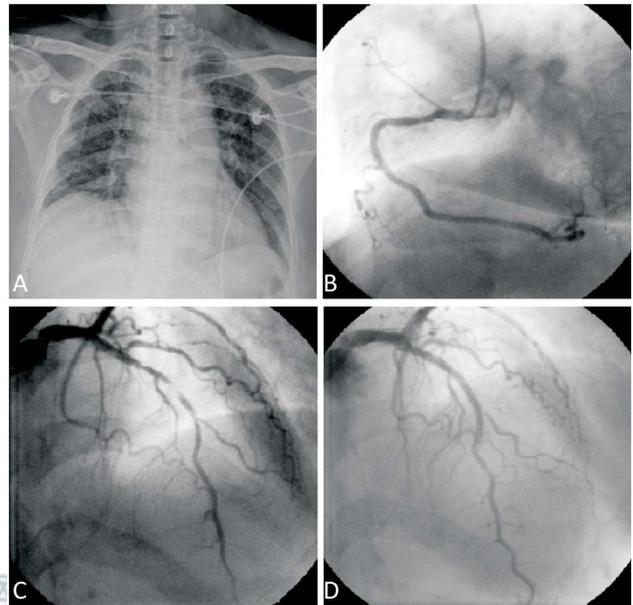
(A) Chest X-ray at emergency department showed mild lung congestion, suggesting reduced cardiac contractility. CAG in the next day revealed (B) RCA atherosclerosis and (C) proximal-to-middle LAD atherosclerosis with more than 90% stenosis and intramural thrombus at middle segment. (D) After PCI with stenting to middle LAD. CAG, coronary angiogram; LAD, left anterior descending artery; PCI, percutaneous coronary intervention; RCA, right coronary artery.
